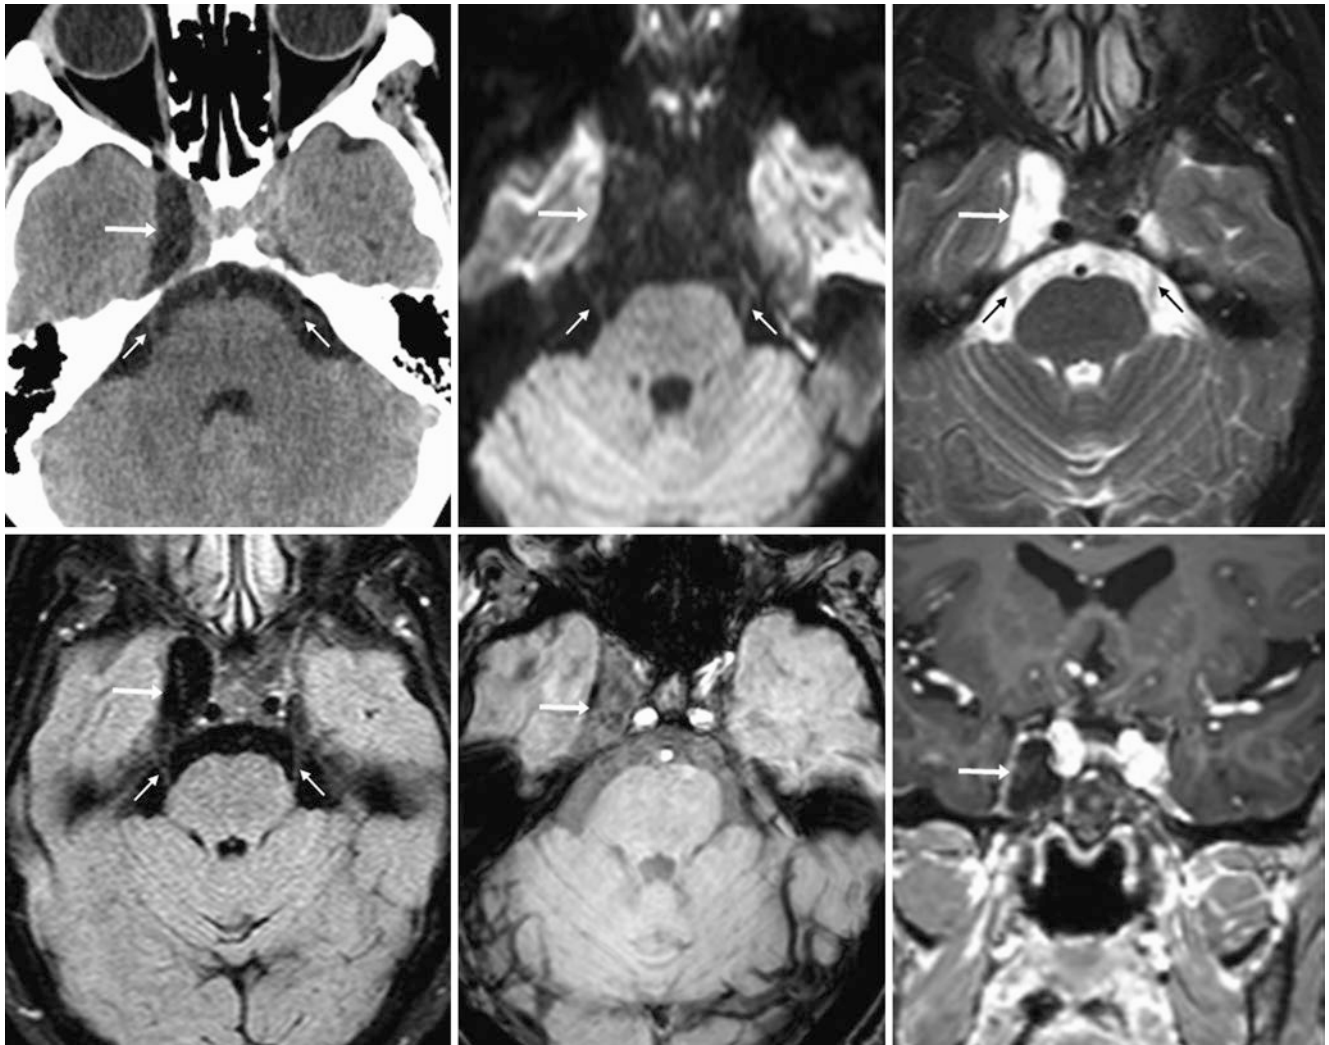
Comparison case of arachnoid cyst (AC). A 60-year-old female patient with headaches had asymmetric enlargement of the right Meckel cave (*arrows*) on axial NECT (*top left*), which on 3 T MRI followed the CSF signal on DWI (*top middle*), T2WI (*top right*), FLAIR
